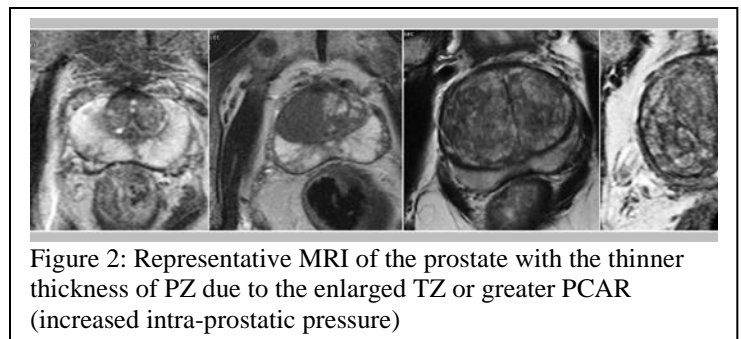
Representative MRI of the prostate with the thinner thickness of PZ due to the enlarged TZ or greater PCAR (increased intra-prostatic pressure)
